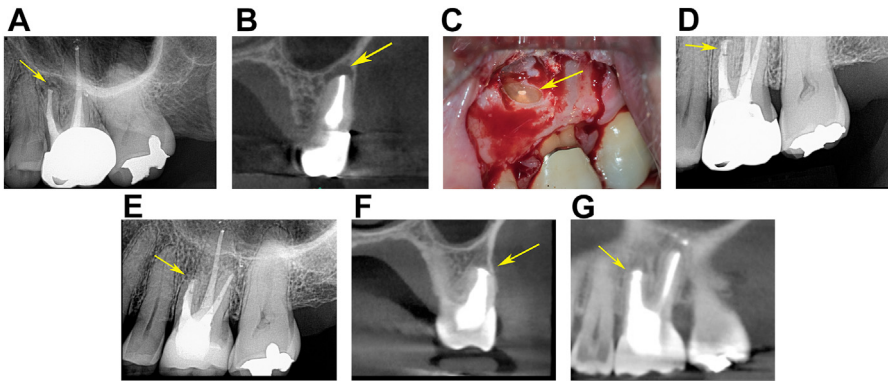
Surgical endodontic treatment (apical surgery, apicoectomy) eliminates a blocked, inaccessible, infected periapical space at the root terminus. (A) Preoperative periapical radiograph showing a maxillary first molar with a periapical radiolucency on the mesiobuccal (MB) root (yellow arrow). (B) Pretreatment cone beam computed tomography (CBCT) frontal capture image showing a definitive periapical radiolucency over the MB root (reversed from image in A). (C) Intraoral photo showing the surgical access, clearance of periapical disease, and apical root resection (yellow arrow). The root canal terminus was later microsurgically prepared and filled with a bioceramic putty. (D) Immediate post-treatment periapical radiograph showing the apically resected and reverse-filled root end (yellow arrow). (E) A 3-year post-treatment radiograph showing osseous regeneration and healing of the periapex (yellow arrow). (F) A 3-year CBCT coronal image showing osseous regeneration of the resected and reverse-filled MB root apex. (G) A 3-year CBCT sagittal image showing osseous regeneration over the resected and reverse-filled MB root apex.
